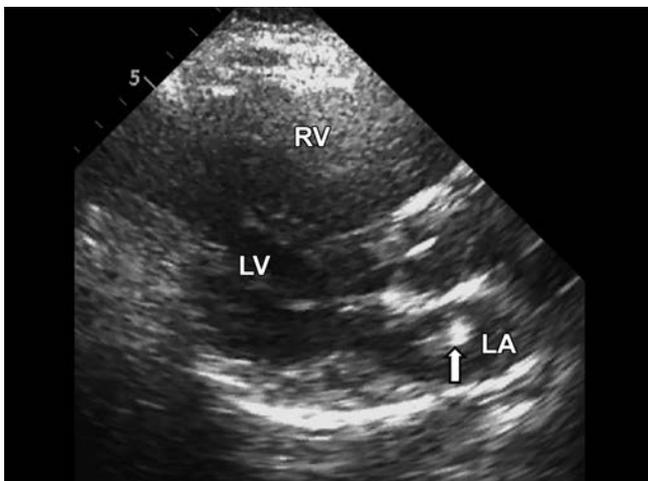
Transthoracic parasternal long axis view. Arrow points to fossa ovalis aneurysm.
